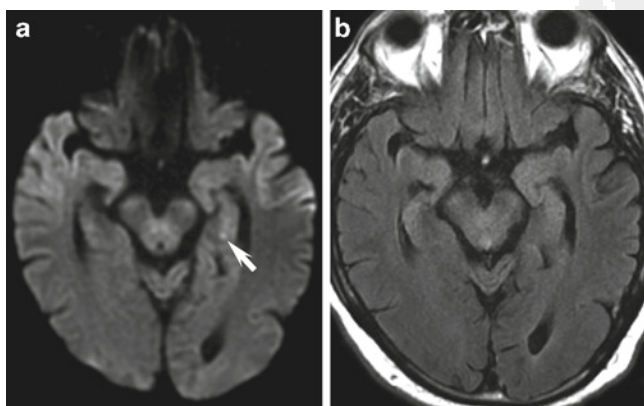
Transient global amnesia (TGA). (a) Axial DWI image from a 64-year-old man presenting with transient memory loss lasting several hours without a focal neurological deficit demonstrates a punctate DWI hyperintense focus in the left hippocampus, an appearance and location typical for TGA (arrow). (b) No abnormality is seen on the FLAIR image. DWI has superior sensitivity to T2 and FLAIR images for detection of the subtle lesions in TGA
